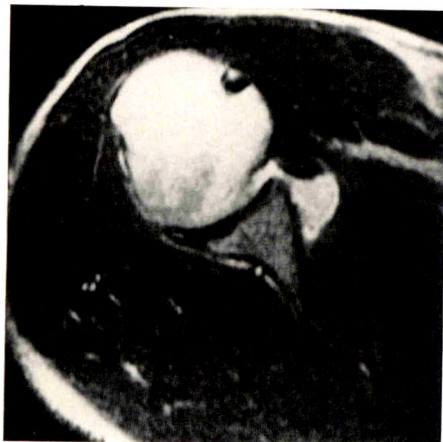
Long TR/TE (2500/80) axial spin-echo MR image shows absent anterior glenoid labrum and detached capsule with effusion. This image is comparable with that seen on CT arthrography in Fig. 7.
